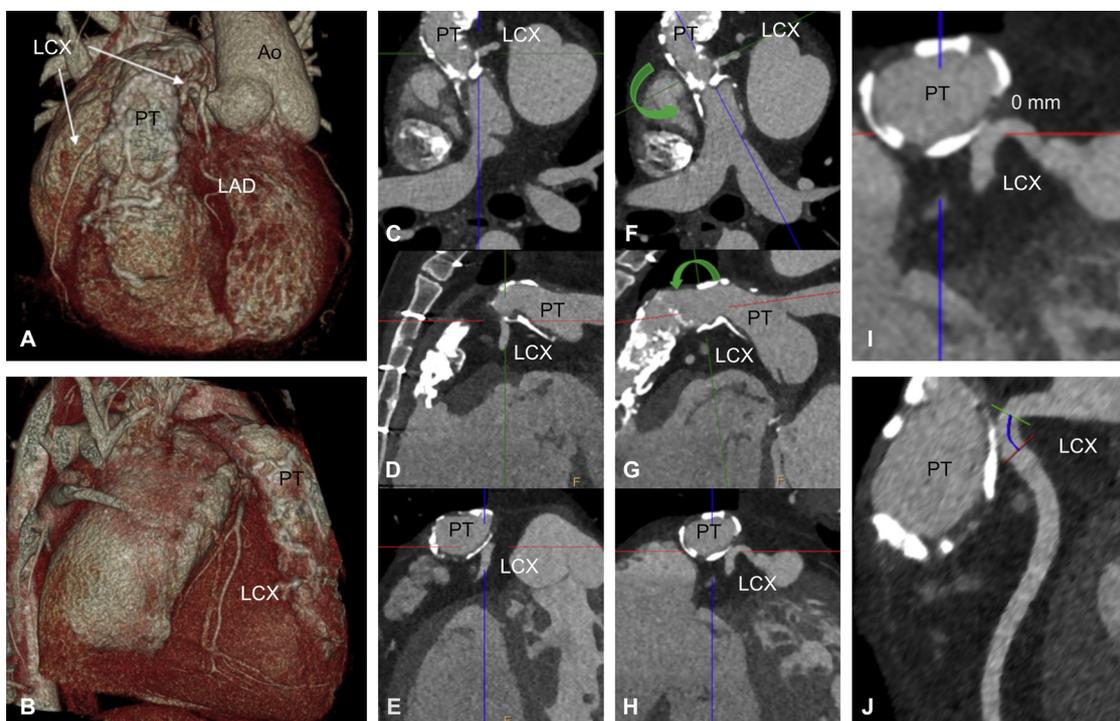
CT Analysis: Relationship between LCX and pulmonary trunk (PT) in a patient with double discordant heart.
